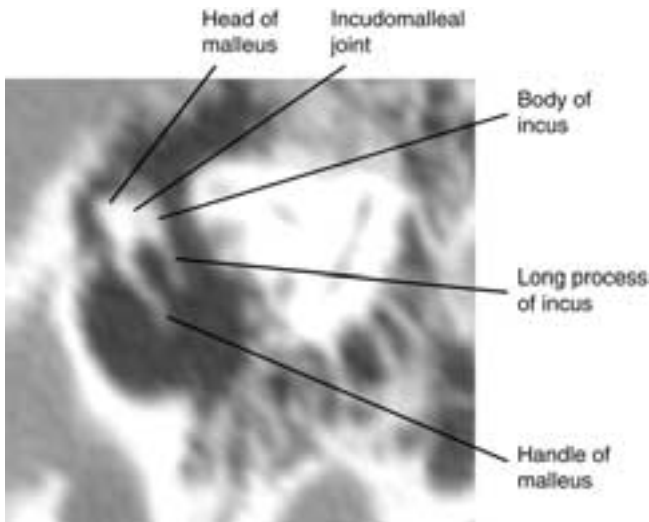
Oblique CT, incus and malleus. This view approximates the otoscopic view from the EAC.
